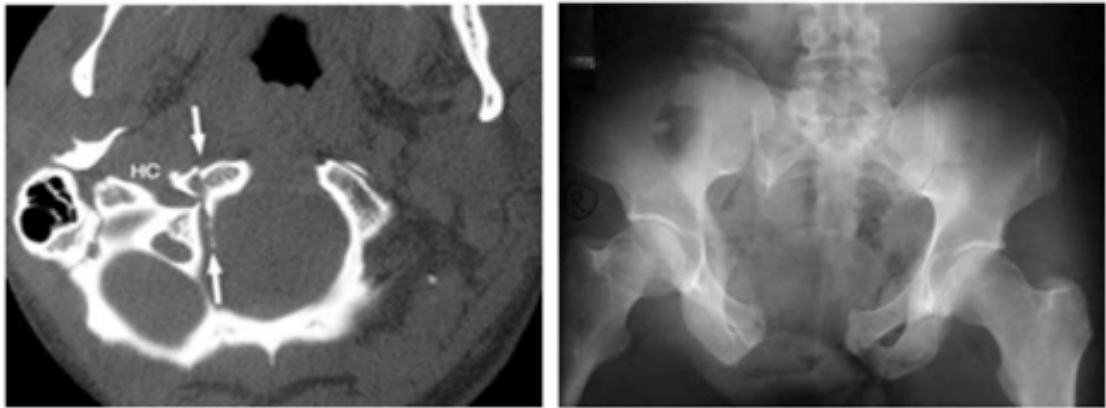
Radiographic images of spinal injuries for pedestrian in Case 1: *left*, axial CT scan shows Type II right occipital condyle fracture extending through skull base; *right*, plain radiograph of open-book pelvic fracture
